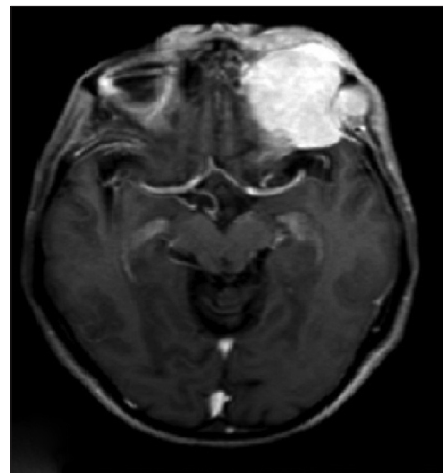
Postcontrast magnetic resonance imaging scan of skull showing well defined lobulated mass in extra-axial space in superior quadrant of left orbit (axial)
